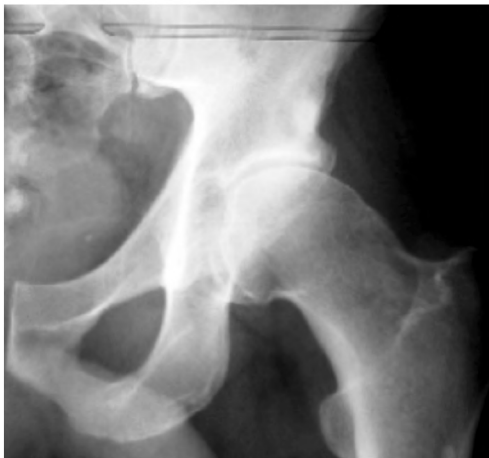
Plain radiography AP view of the left hip shows pistol grip deformity of proximal femur in patient with cam type (FAI).
